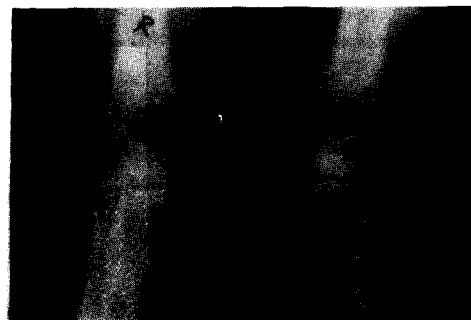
Radiograph of both elbow joints demonstrates:
